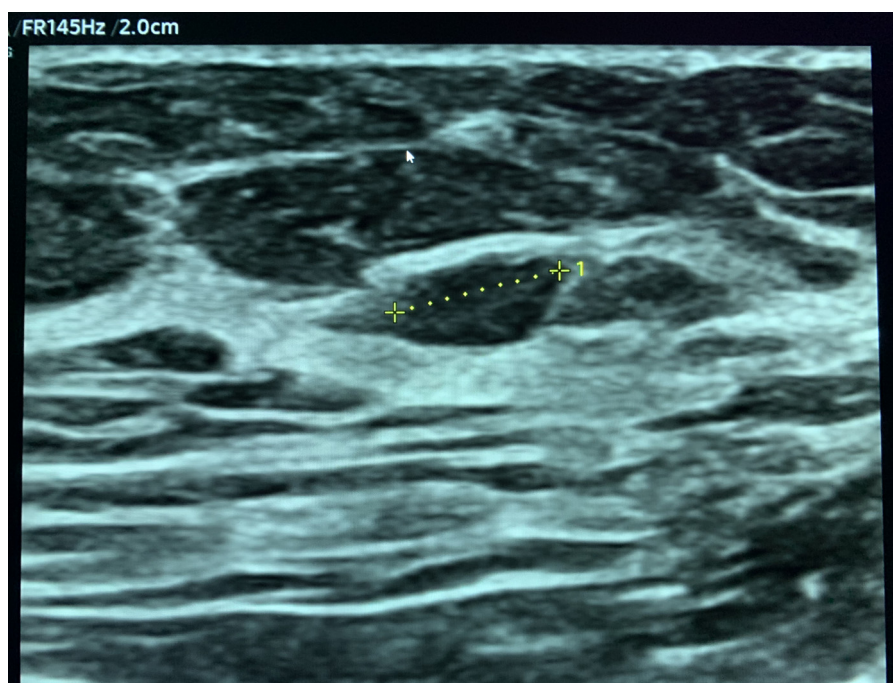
Ultrasound images showing a well-defined hypoechoic nodule corresponding to the mammographic abnormality, which was suspicious for a lymph node.
